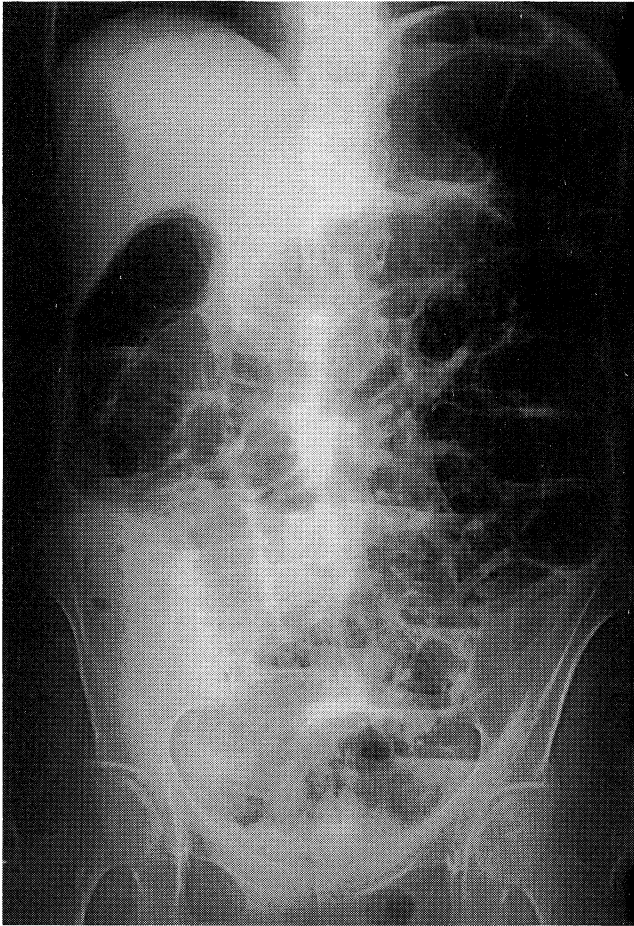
A plain abdominal roentgenogram showed marked extension of bowels, including small intestine and colon, diagnosed as ileus.
